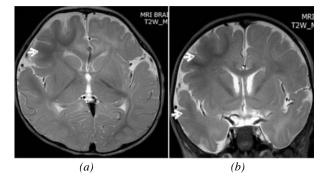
Brain MRI T2 weighted axial (a) and coronal images (b) of case 1 showing the right hemispheric dysplasia seen as fronto-temporal hypermyelination (hypointense white matter)-hallmark of dysplasia in infancy.
